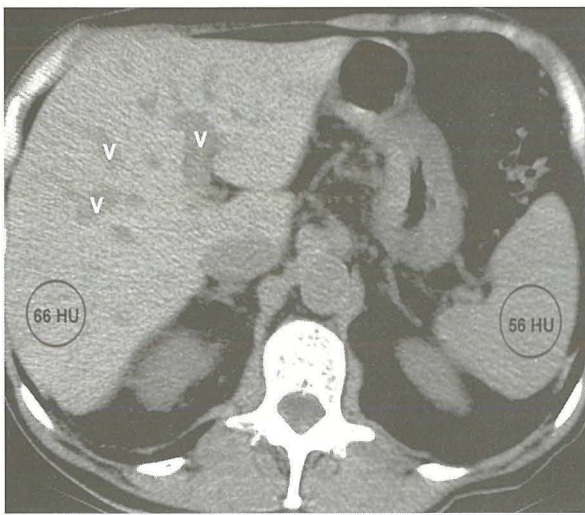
Normal density of the liver at unenhanced CT (66 HU) is slightly higher than that of the spleen (56 HU), and intrahepatic vessels (v) appear hypodense in comparison with the liver.
